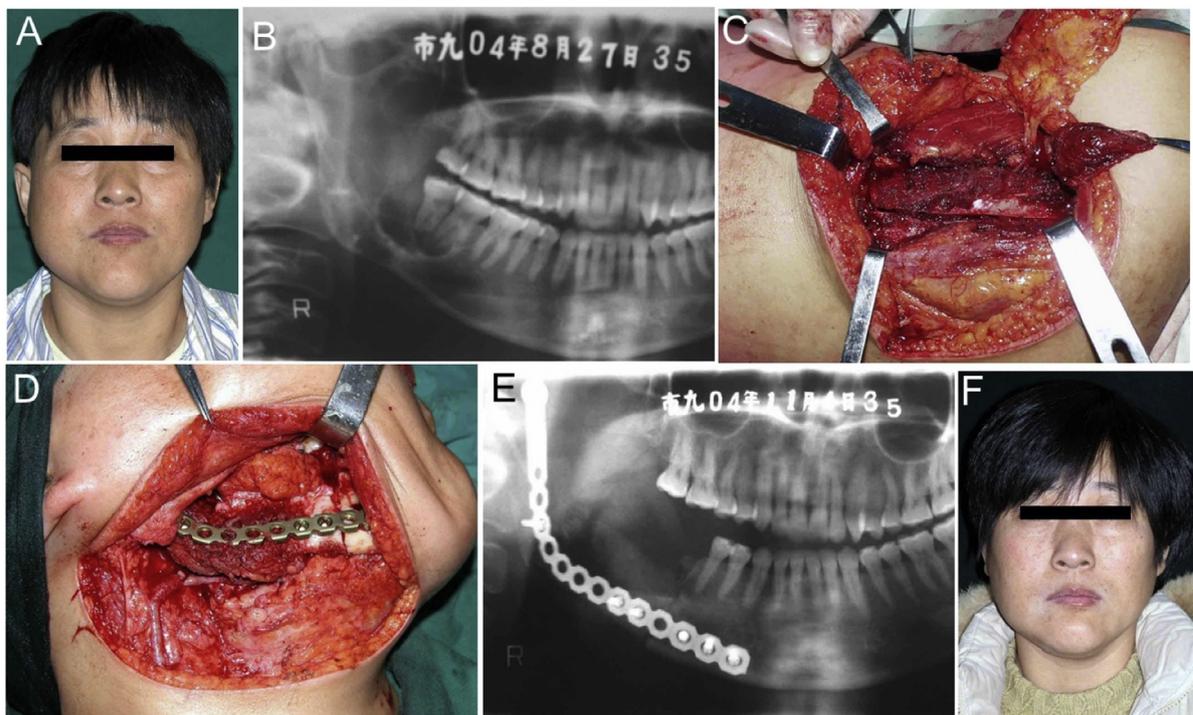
A 42-year-old female patient with ameloblastoma of the left mandibular angle and ramus. (A) Facial photograph before surgery; (B) panoramic radiograph showing ameloblastoma of the left mandibular angle and ramus; (C) harvest of the scapula myocutaneous flap; (D) mandibular reconstruction with the scapula flap; (E) postoperative radiograph and (F) facial photograph showing an excellent postoperative appearance.
